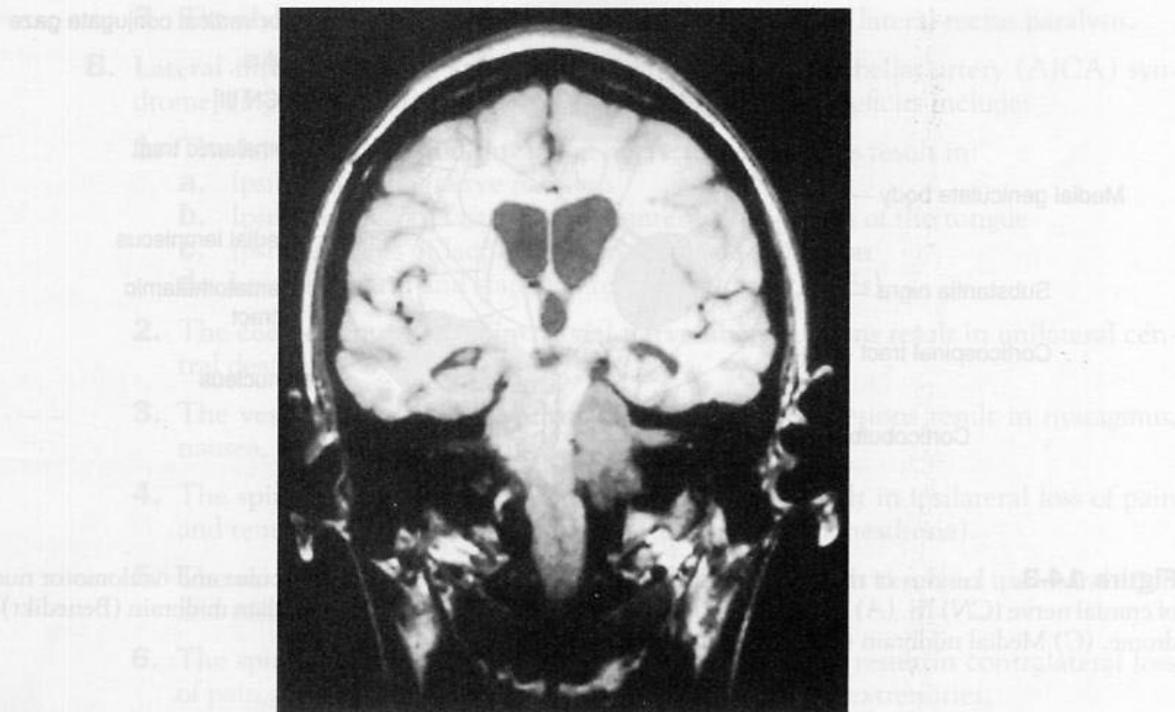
Magnetic resonance image of an acoustic neuroma. This coronal section shows dilation of the ventricles. The vestibulocochlear nerve is visible in the left internal auditory meatus. The tumor indents the lateral pons. Cranial nerve (CN) palsies include CN V, VII, and VIII. Symptoms include unilateral deafness, facial anesthesia and weakness, and an absent corneal reflex. This is a T1-weighted image.
